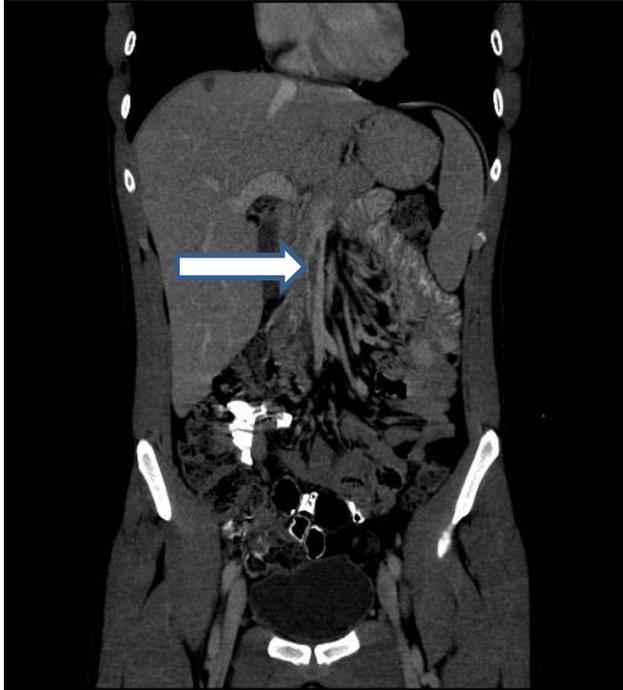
Coronal projection of a CT scan of the abdomen, with contrast, showing a filling defect in the superior mesenteric vein indicating partial thrombosis of the vein.
